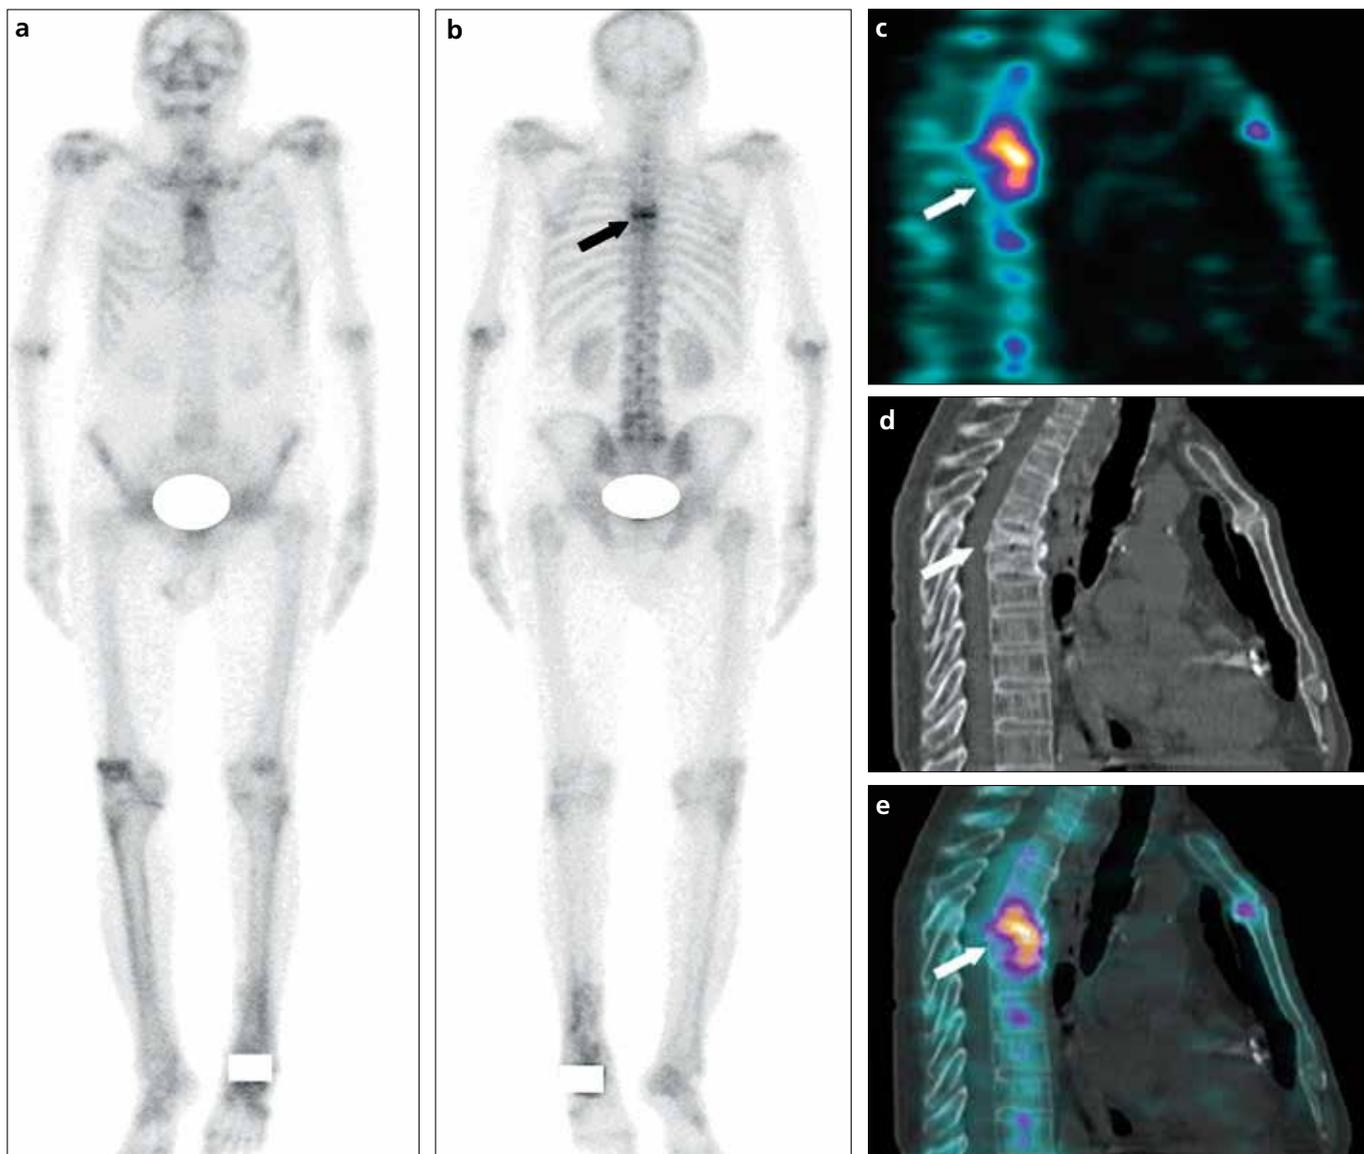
a–e. A 63-year-old male patient presented with multiple bone pain. Bone scintigraphy was performed to rule out bone metastasis. Planar bone scintigraphy images (a, b) show uptake in the T5 vertebra (arrow; score 2). Sagittal SPECT (c) image shows linear uptake in the body of the T5 vertebra (arrow; score 5). Sagittal CT (d) and SPECT-CT (e) images show the anterior wedge collapse of the T5 vertebra with increased tracer uptake (arrow; score 5). In these images, SPECT, CT, and SPECT-CT characterized the planar scintigraphy most likely metastatic lesion as benign.
